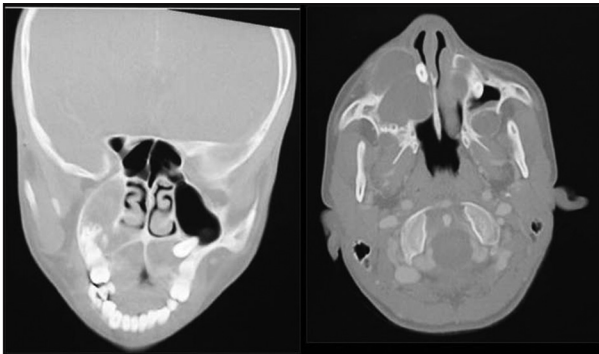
Computed tomography coronal and axial sections showing well-defined corticated hypodense expansile lesions involving right and left side of the maxilla
